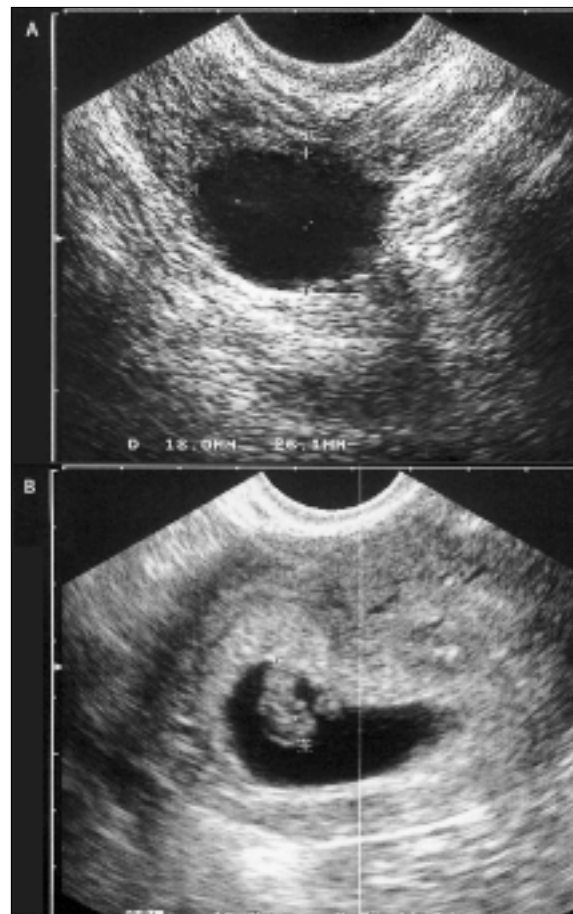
Vaginal ultrasonography
